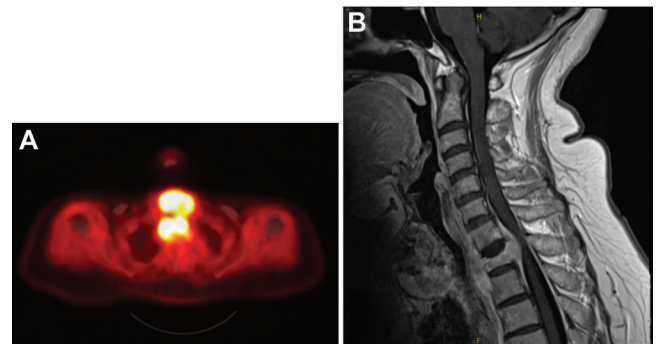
(A) Positron emission tomography shows a hypermetabolic thyroid mass (standardized uptake value, 10.8) and lytic vertebral lesion (standardized uptake value, 11.9). (B) Magnetic resonance imaging shows a thyroid mass with a central lesion causing collapse of T1 vertebra, leading to a “vertebra plana” appearance.
